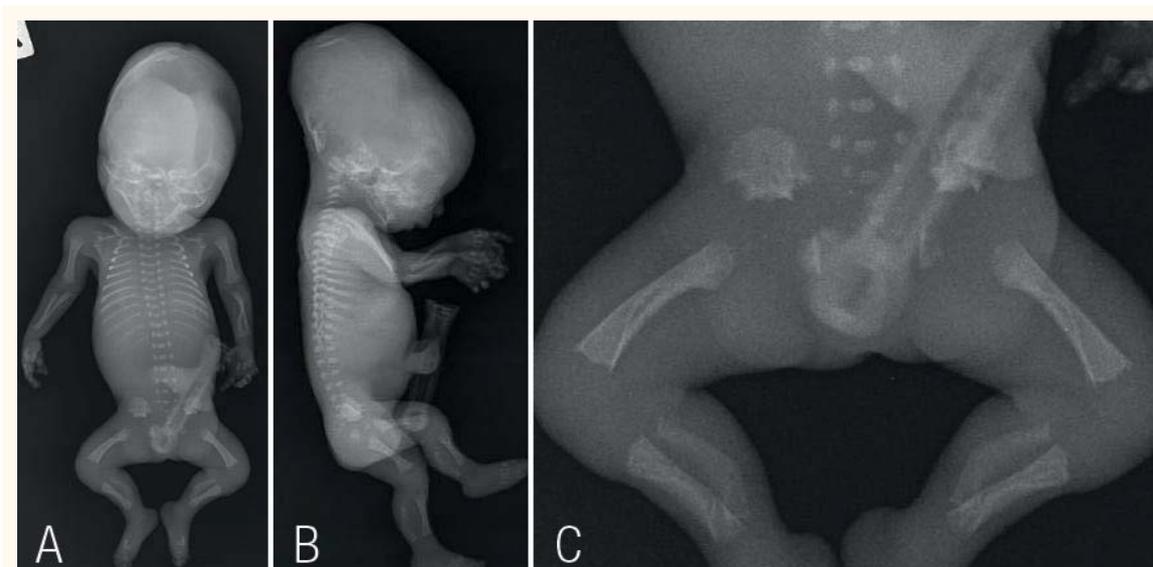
Fetal phenotype: skeletal radiographs of anteroposterior (I), lateral (II) and pelvic (III) views.
